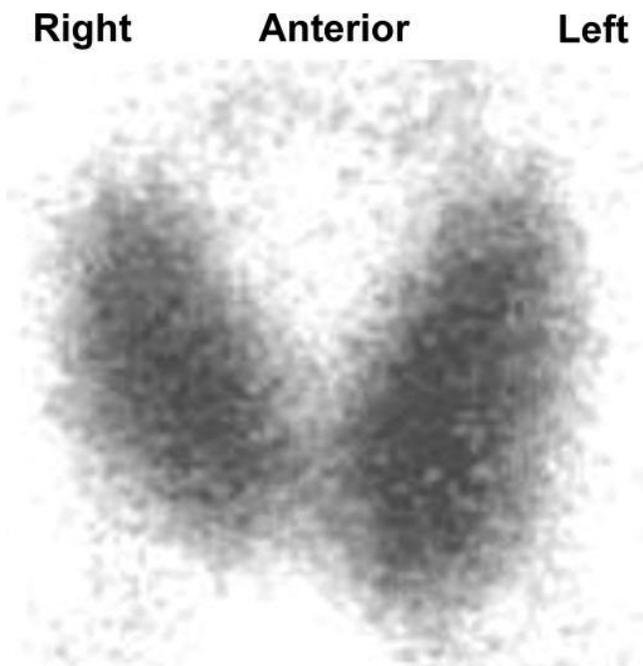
$^{99\text{m}}\text{Tc}$ -pertechnetate scintigraphy of the thyroid after lithium was discontinued showing diffuse uptake; 24 hour RAI uptake with 15 μci of ^{131}I was 31.2%.
